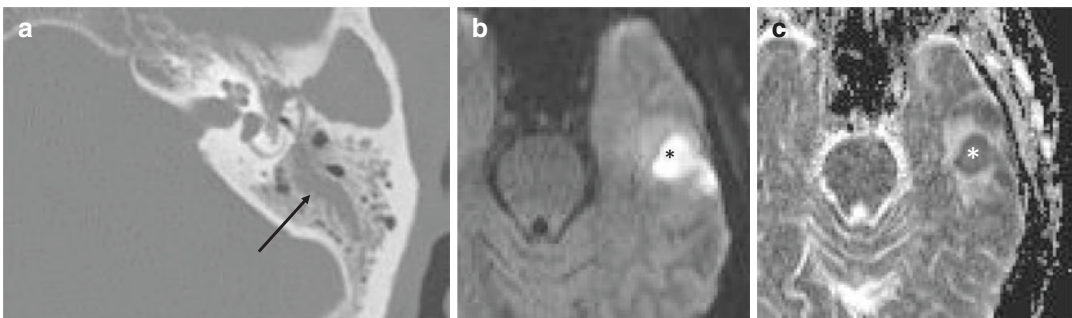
(a) Axial CT bone window showing a left mastoid effusion (black arrow). (b) Axial DWI at a higher level showing elevated signal in the left temporal lobe
